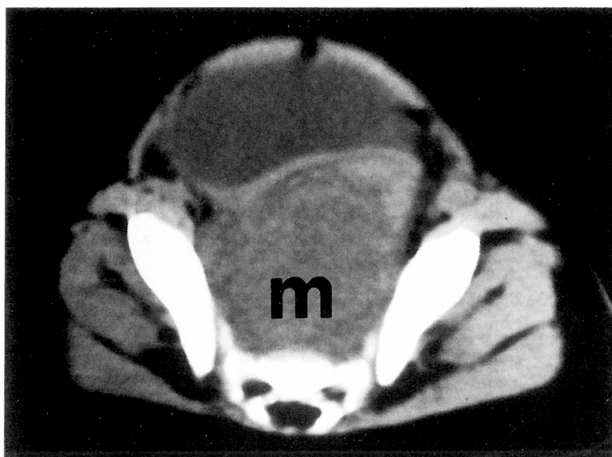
CT. Large, inhomogeneous, hypodense soft tissue mass occupying the pelvic cavity.
